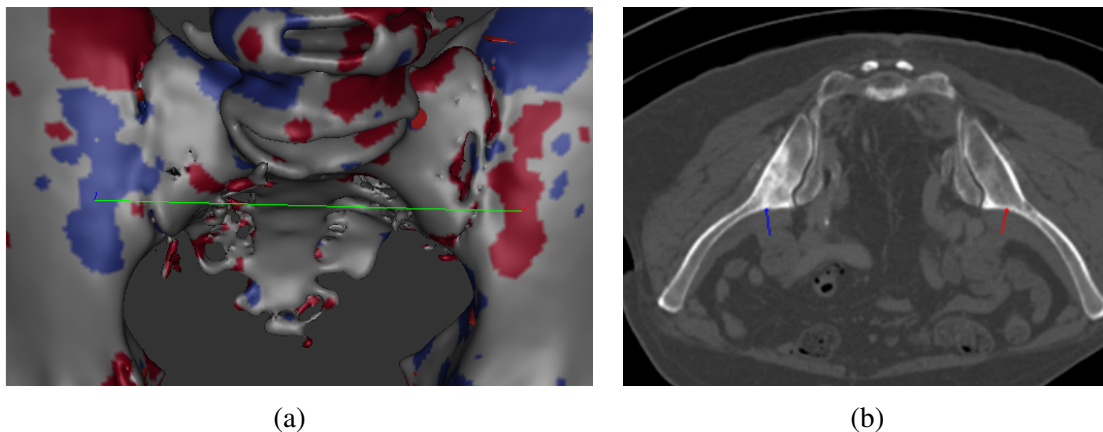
An example of mapping the 3D visualisations back to the original CT images. On the left, a user has clicked on a diseased region (shown by the red surface normal line). On the right, this diseased data is shown in the resliced CT data (which is the plane defined by the vector found by averaging the red and blue surface normal vectors and by the vector of the green line connecting the two points). The CT data is from the Addenbrooke's Hospital CT Data Collection. Image is a screenshot taken of the custom image viewer.
